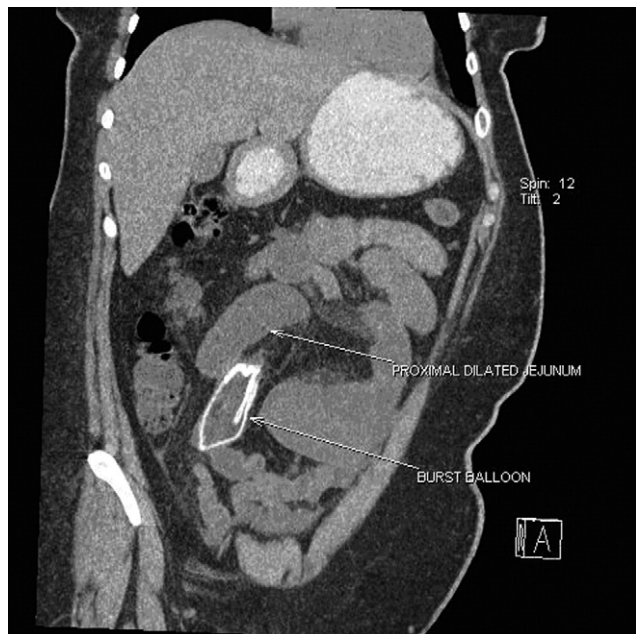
Computed tomography scan showing dilation of proximal intestine.
